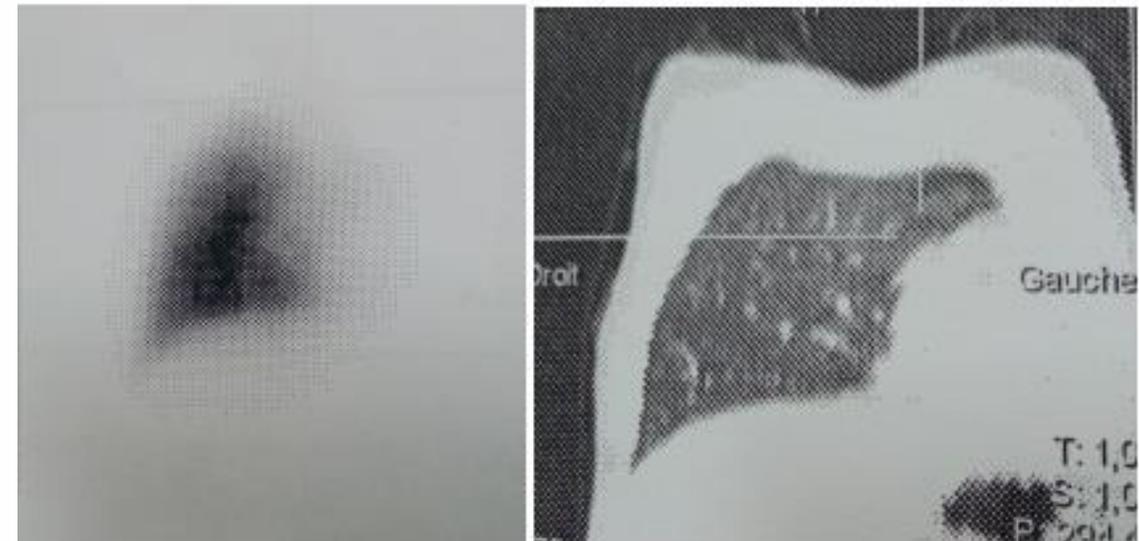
pulmonary perfusion SPECT-CT showing a perfusion defect of the most of the left lung with a function $<10\%$.
